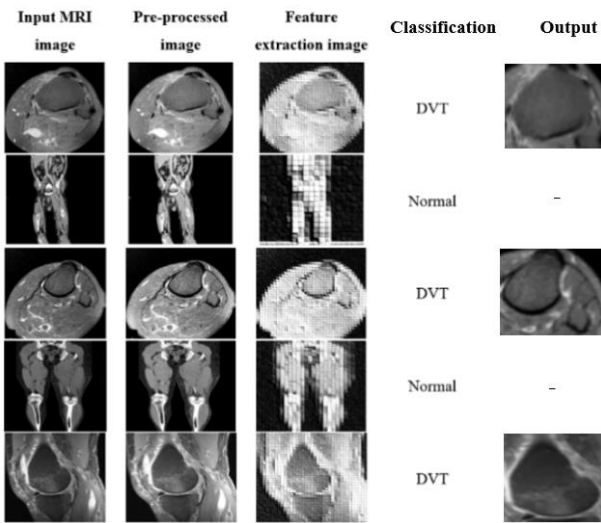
The experimental results of the proposed Deep Vein Net model using MRI images.
